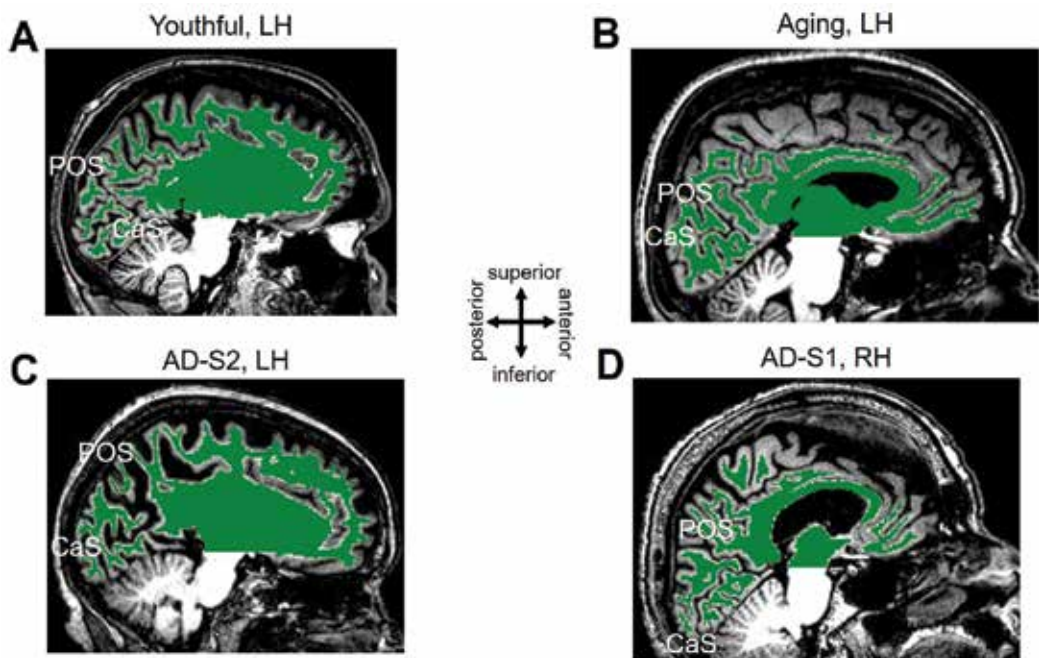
White/gray matter segmentation for young, healthy aging, and mild Alzheimer's disease subjects. Each panel is a T1-weighted 3D MPRAGE image showing a sagittal slice near the midline of the brain. Green-colored overlay represents white matter identified by an automated algorithm [104] and adjusted by hand-editing to minimize segmentation errors [1, 3, 92]. White regions below the green overlay represent unsegmented white matter within the cerebellum. Gray matter is shown as the gray regions along the surface of the green overlay and adjacent to the black cerebral spinal fluid (CSF; *black regions within the skull*). Middle inset displays approximate anatomical directions. CaS: calcarine sulcus; POS: parietal-occipital sulcus. (A) Left hemisphere of healthy young subject. (B) Left hemisphere of healthy aging subject. (C) Left hemisphere of a subject with mild Alzheimer's disease (AD-S2). (D) Right hemisphere of a second subject with mild Alzheimer's disease (AD-S1). Note how AD-S1's anatomy is relatively intact, but the visual field map measurements from this subject shown in Figure 12 are perceptibly abnormal. Also compare the strikingly increased CSF-filled space in this T1 image of AD-S2 to the relatively normal visual field map organization for this subject in Figure 12. Data were adapted from [36, 37].
